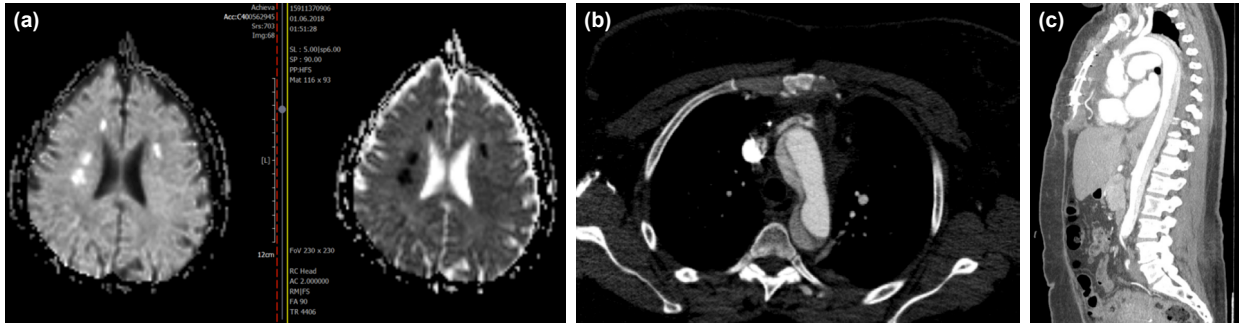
(a) Diffusion MR imaging. (b) Aortic dissection seen on the bifurcation of aorta. (c) Aortic dissection, true and false lumens seen on CT.
